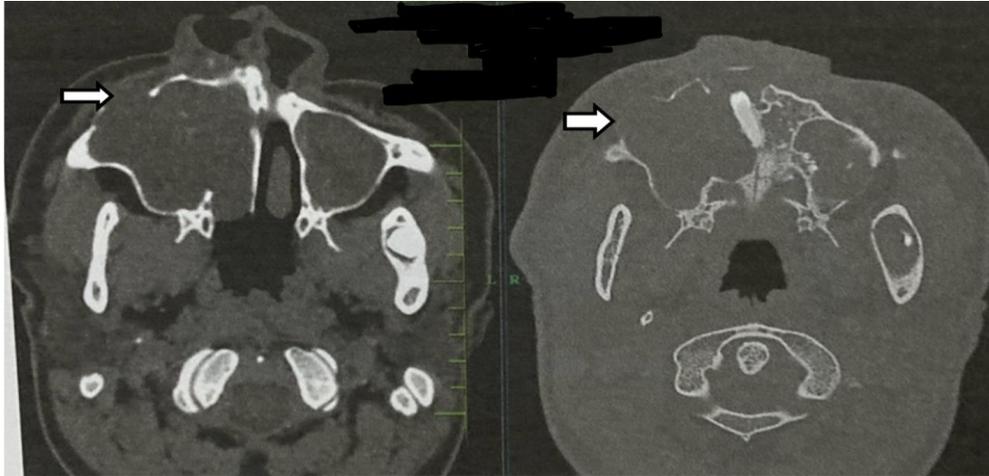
CT image of paranasal sinuses
